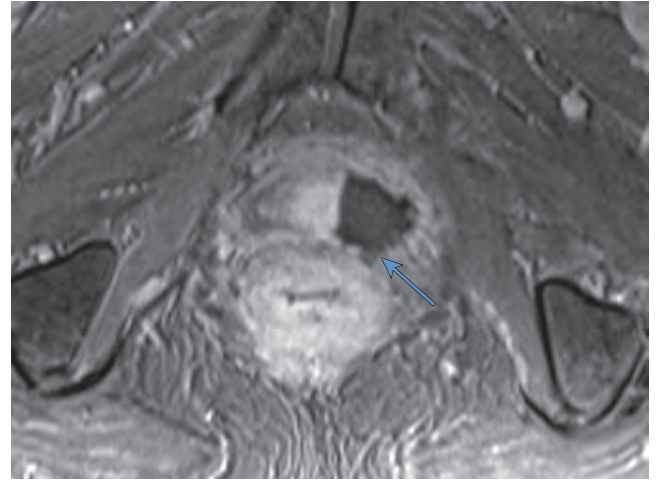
The man with radiorecurrent disease in Figures 117-50 to 117-53 underwent focal high-intensity focused ultrasound (HIFU) ablation using a hemiablation strategy. He was impotent before the HIFU treatment, but he remained pad free and leak free following treatment. The dynamic contrast-enhanced magnetic resonance image shows good ablative effect with absence of blood supply in the treated side. Post-treatment PSA values decreased to 0.2 ng/mL, 0.9 ng/mL, 0.5 ng/mL, and 0.03 ng/mL, measured trimonthly.
